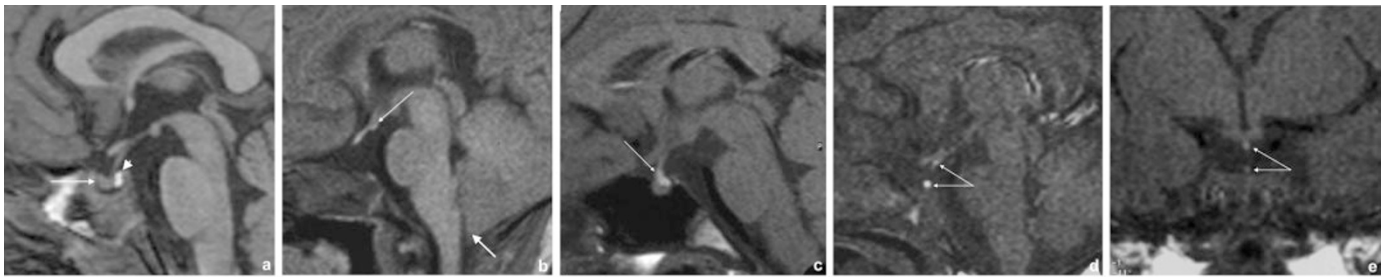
Variable location of the ectopic neurohypophysis on MRI. (A) Normal appearance of pituitary gland in a 7-y-old child. Anterior pituitary gland (*arrow*) Hyperintense posterior pituitary gland (*arrowhead*) (B) Patient 4, T1 weighted sagittal slice. Hypoplastic anterior pituitary, no pituitary stalk being visible (even after gadolinium injection). The hyperintensity of the ectopic pituitary is at the median eminence (*arrow*). Associated abnormalities were shallow sella turcica and Arnold Chiari malformation (*large arrow*). (C) Patient 12, T1 weighted sagittal slice. The hyperintensity of the ectopic neurohypophysis is visible in the distal portion of the pituitary stalk and communicates with an intrasellar neurohypophysis (*arrow*). The anterior pituitary and the pituitary stalk have a normal appearance. (D,E) Patient 8, T1 weighted sagittal and coronal slices. Double ectopic hypersignal of the neurohypophysis in the distal and the proximal portions of the pituitary stalk.
